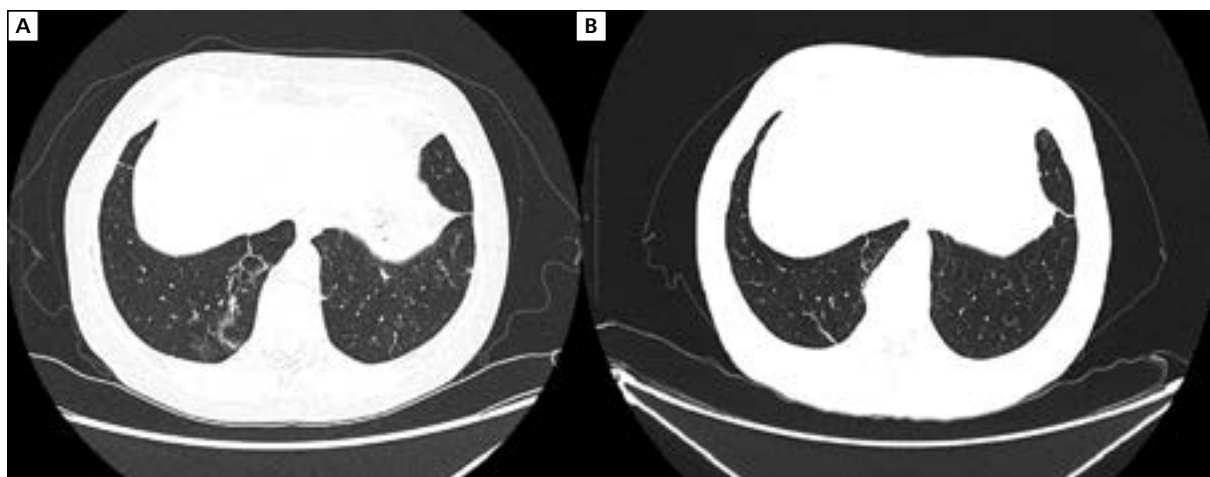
Computed tomography (CT) scan images; A. Inflammatory changes in the patient's lungs; B. Complete regression of inflammatory lesions
